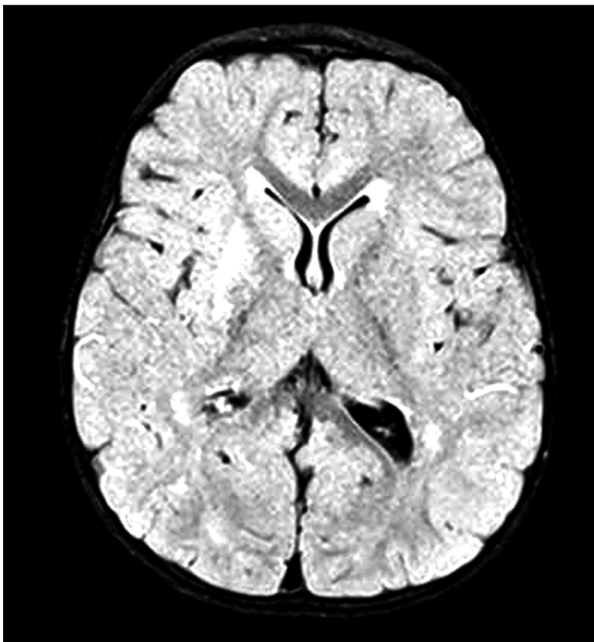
Axial fluid-attenuated inversion recovery magnetic resonance imaging (MRI) on the first presentation of a patient with moyamoya disease. The image shows hyper intense foci in right basal ganglia as a result of decreased perfusion from moyamoya disease.
